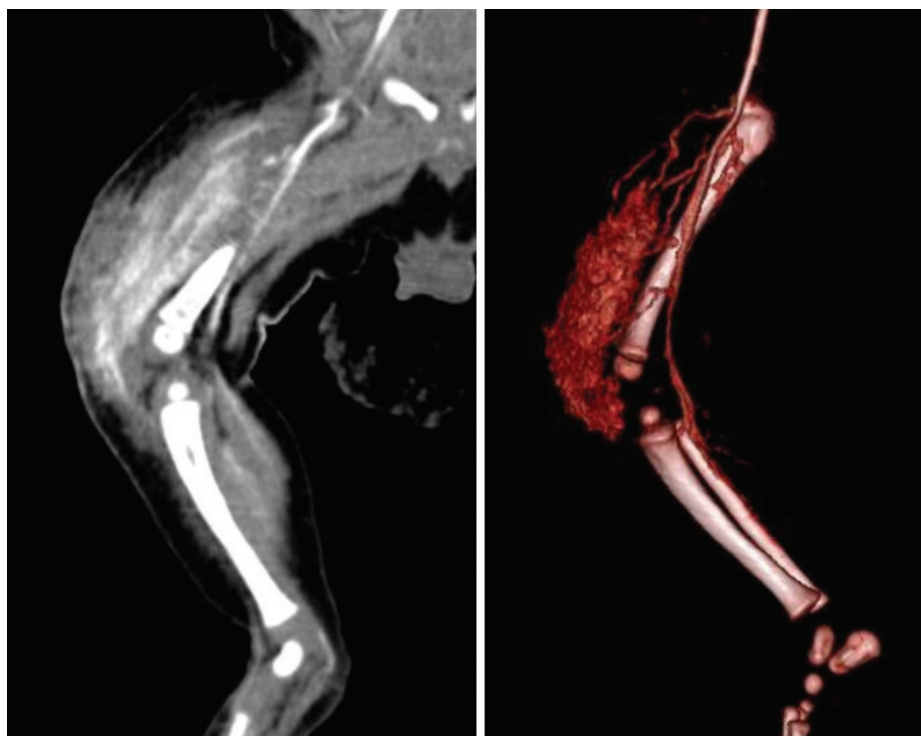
A) (MPR coronal plane CT angiography with hip in abduction position) and B) (3D Volume rendered CT Angiography) show a hypervascular mass lesion in anterior and lateral muscular compartment of middle and inferior part of thigh and knee joint. Multiple tortuous arterial feeders from superficial and deep femoral, as well as popliteal arteries feed the lesion
